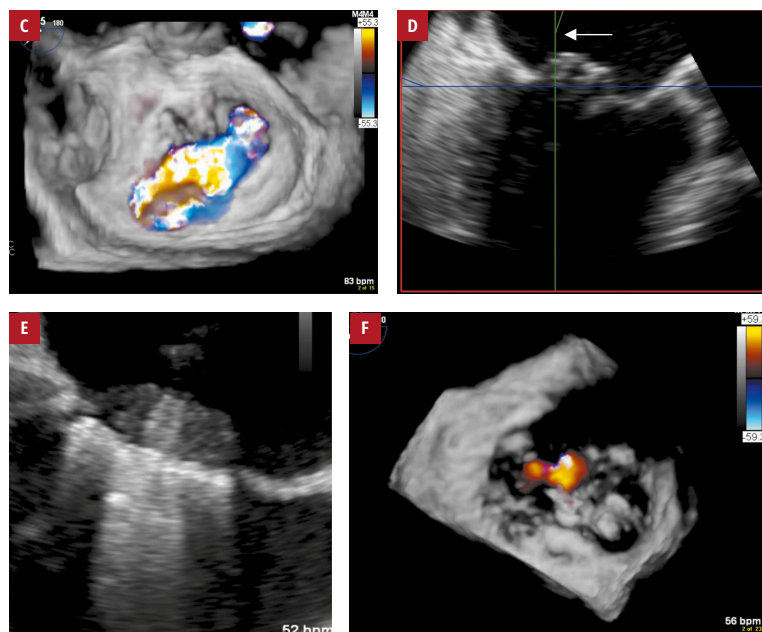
Transesophageal echocardiography: C – a 3-dimensional color image confirming the jet direction; D – three-dimensional reconstruction with the coaptation line crossed, showing the true orthogonal plane. The arrow indicates the posterior prolapse of the medial mitral segment; E – view of the left ventricular outflow tract showing grasping over the anterior and posterior prolapsed mitral leaflets at the medial segments; F – a 3-dimensional color image demonstrating mild mitral regurgitation after placing 2 clips
